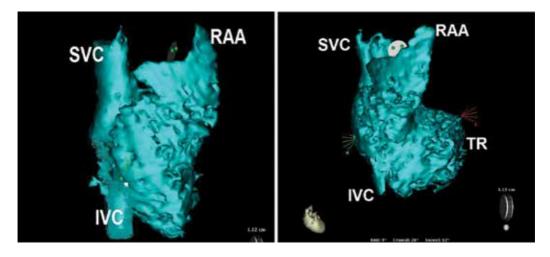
Computed tomography of the right atrium (the contrast substance from the cavity is subtracted and gives an image similar to an internal cast). (A) RAO view; (B) anterior view. The right atrial appendage (RAA) is an anterior structure. TR = tricuspid valve, IVC = inferior vena cava, SVC = superior vena cava.
